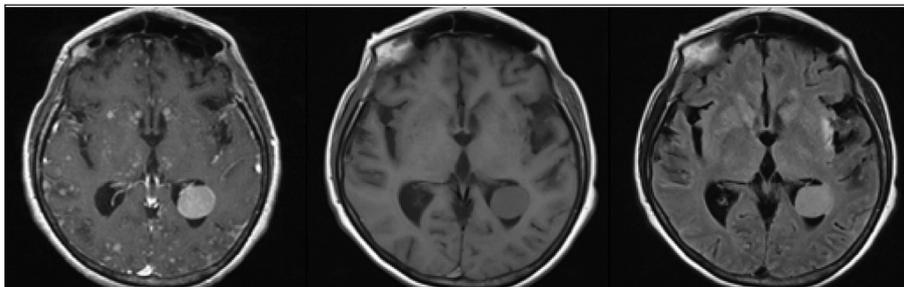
Gadolinium-enhanced T1-weighted magnetic resonance imaging showing multifocal ring-enhancing lesions, but no changes seen on non-enhanced T1-weighted magnetic resonance imaging and fluid attenuation recovery images.
